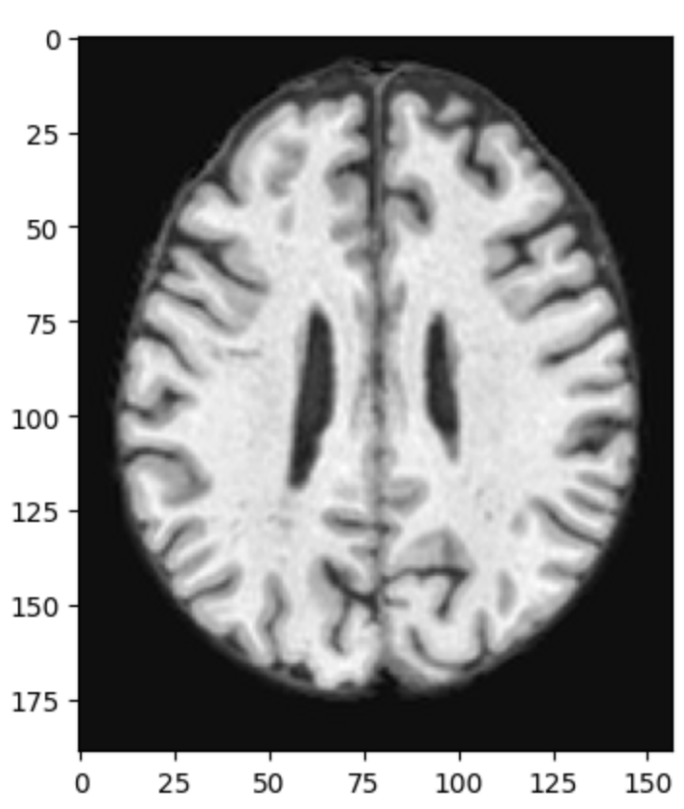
Rectangular Preprocessed MRI of height 189 units and width 156 units
